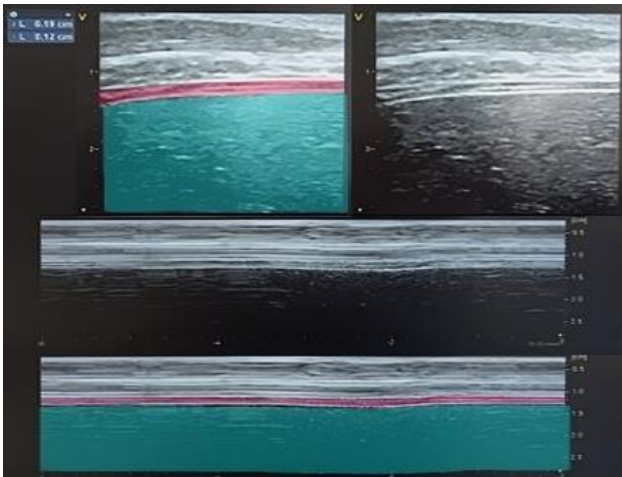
Ultrasound performed before application of TMP (rapid shallow breathing index & diaphragmatic thickening fraction observed by t1-weighted ultrasonography by M-mode [highlighted in red-diaphragm muscle & blue-liver]) (Source: Authors' own elaboration)
